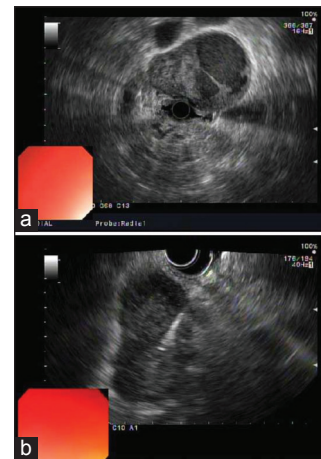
Image of a large gastrointestinal stromal tumor. (a) Endoscopic ultrasound (EUS); (b) EUS-guided fine-needle aspiration
